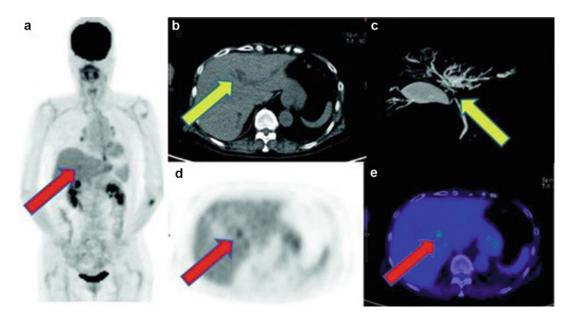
IgG₄-related sclerosing cholangitis. Non-contrast CT and MRCP show intrahepatic bile duct dilatation due to hepatic hilar severe stenosis (b, c; *yellow arrows*). [¹⁸F] FDG accumulates on the point of hepatic hilum (a, d, e; *red*
